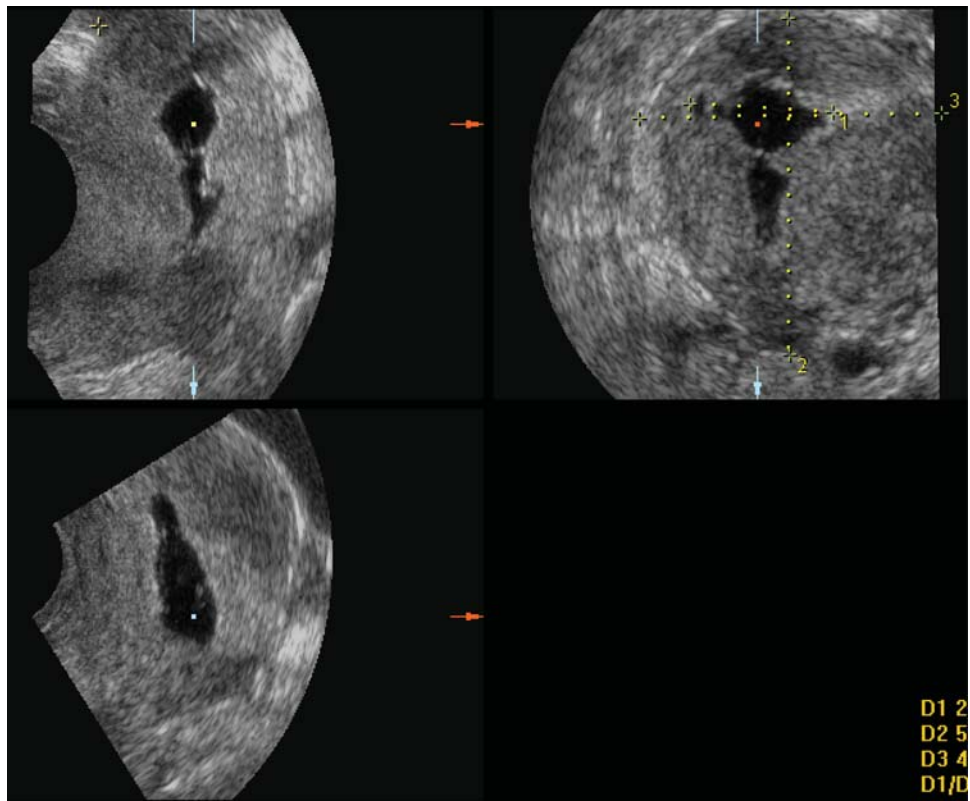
Hysterosonography of T-shaped uterus.
